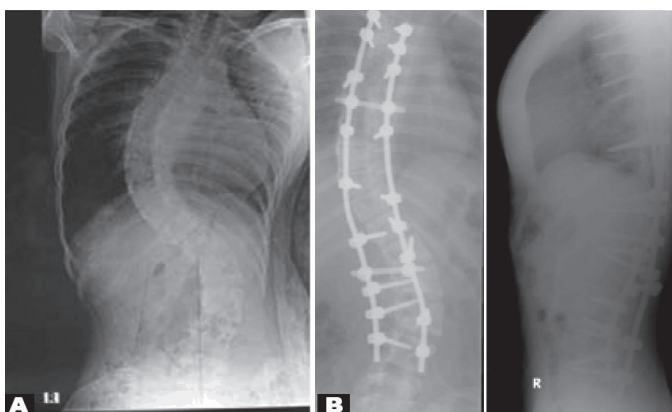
(A and B): Seventh patient case presentation: X-ray pre- (A) and post-operative (B).
